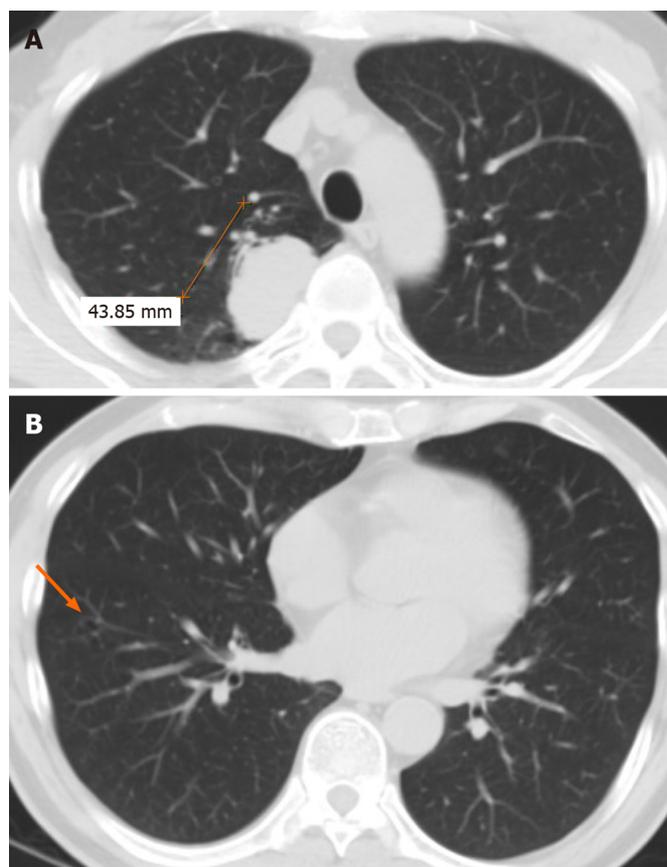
Chest computed tomography scan in 2007 showed a 43-mm solid lesion in the right upper lung and a small thin-walled cavity in the lower lobe. A: A 43-mm solid lesion in the right upper lung; B: A small thin-walled cavity in the lower lobe (arrow).
